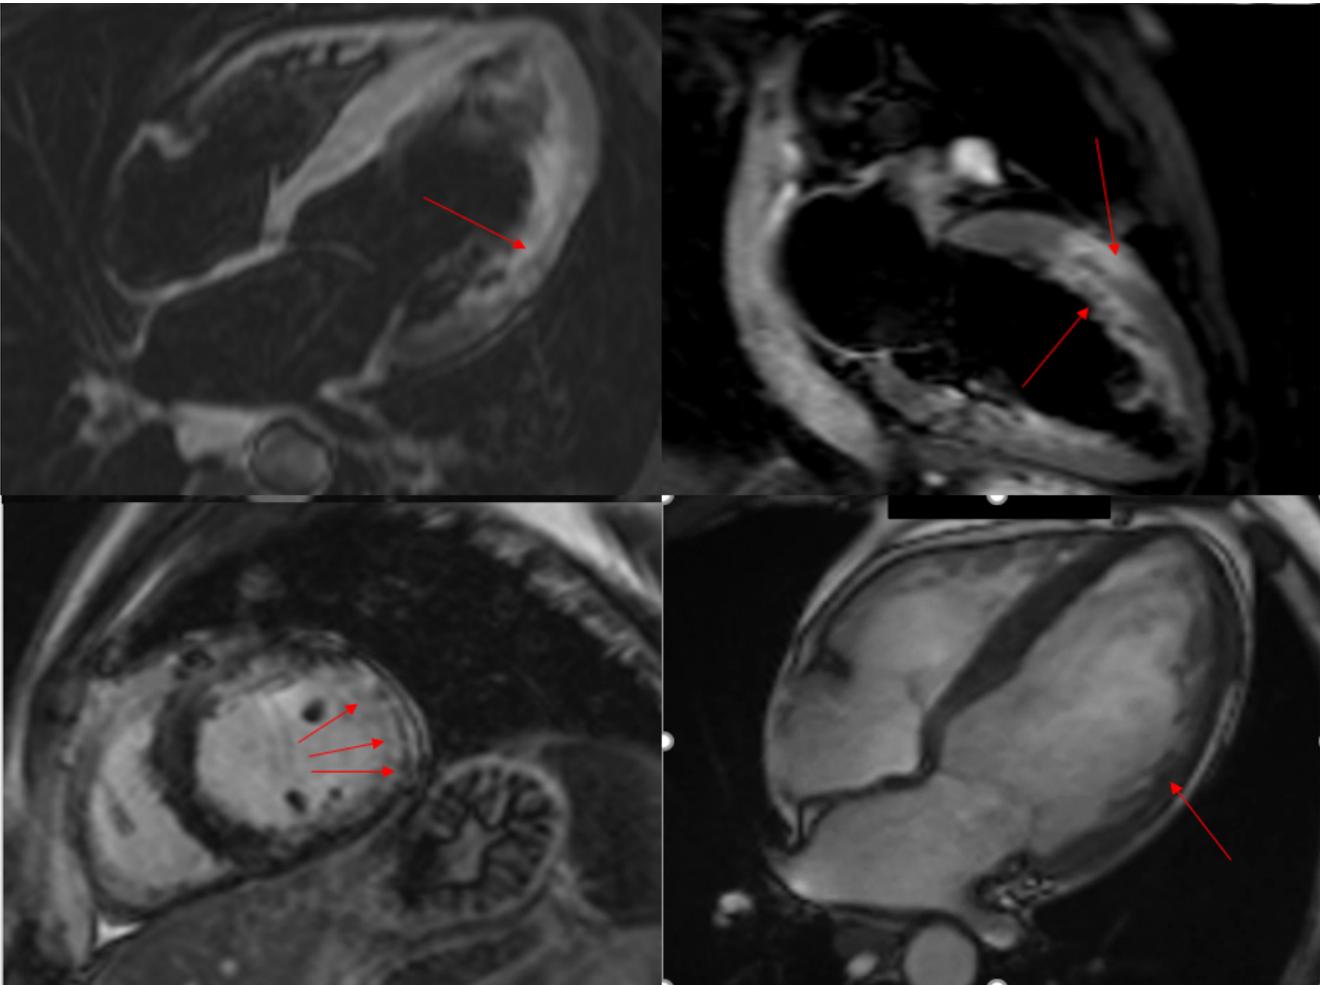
Cardiac MRI – Mild LV dilation; LVEF – 43 %; Multiple areas of LGE along the middle third of antero-lateral and lateral wall
